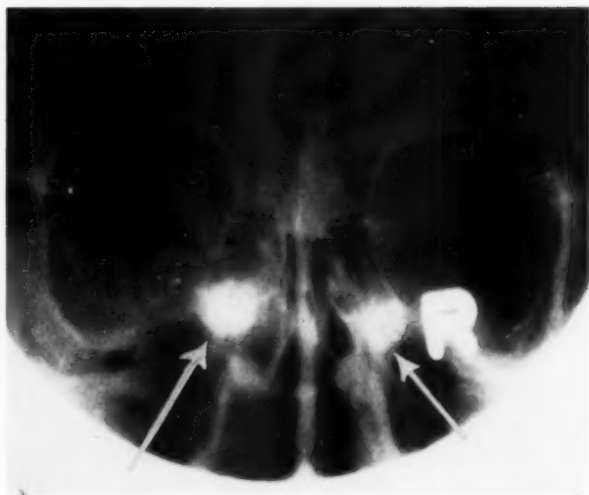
X-ray showing lipiodol in ethmoids.
